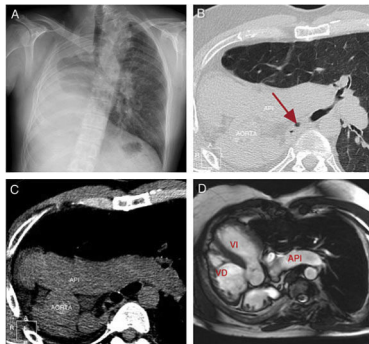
(A) Chest X-ray, posteroanterior projection, showing mediastinal and left lung shift toward the right hemithorax caused by absence of the right lung (pulmonary agenesis). (B) Tomographic axial slice showing lung parenchyma view. The arrow indicates the rudimentary right main bronchus terminating in the pleural sac. (C) Tomographic axial slice without intravenous contrast showing the shift of vascular structures toward the right hemithorax, and absence of right pulmonary artery. API: Left pulmonary artery. (D) Cine-MR b-FFE oblique axial slice. Dextrocardia, dextro-apex and complete absence of right lung parenchyma are observed. VD: right ventricle; VI: left ventricle.
